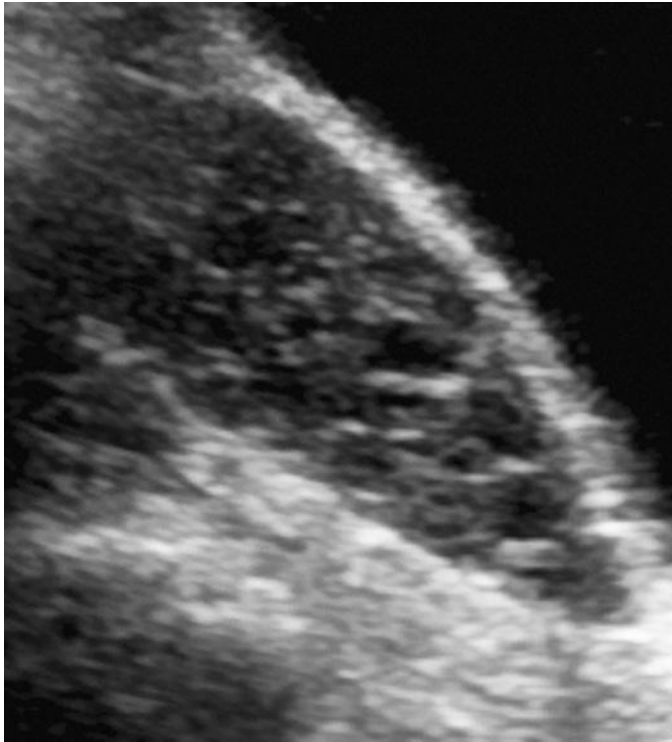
Polycystic ovary syndrome in a 14-year-old girl with obesity, hirsutism, and irregular menstrual periods. Sagittal ultrasound image demonstrates an enlarged right ovary (volume 20.3 mL) with numerous small, intraparenchymal follicles. See Video 34-4.
